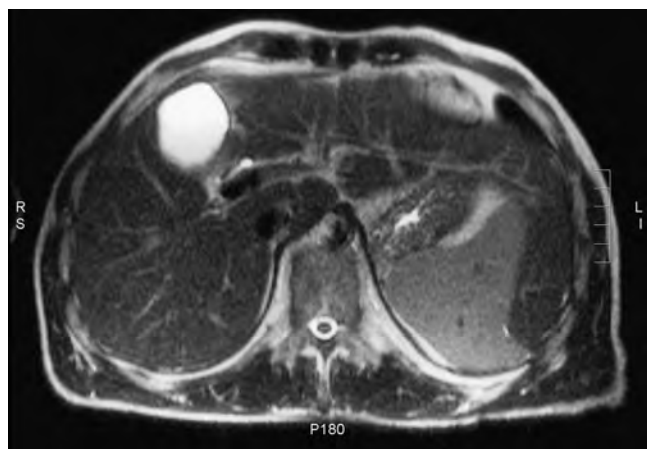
Sliver of liver. The T2-weighted image of the upper abdomen reveals leftward lateral extension of the left lobe of the liver, which appears as a crescentic low-intensity structure wrapping around the lateral aspect of the spleen.
